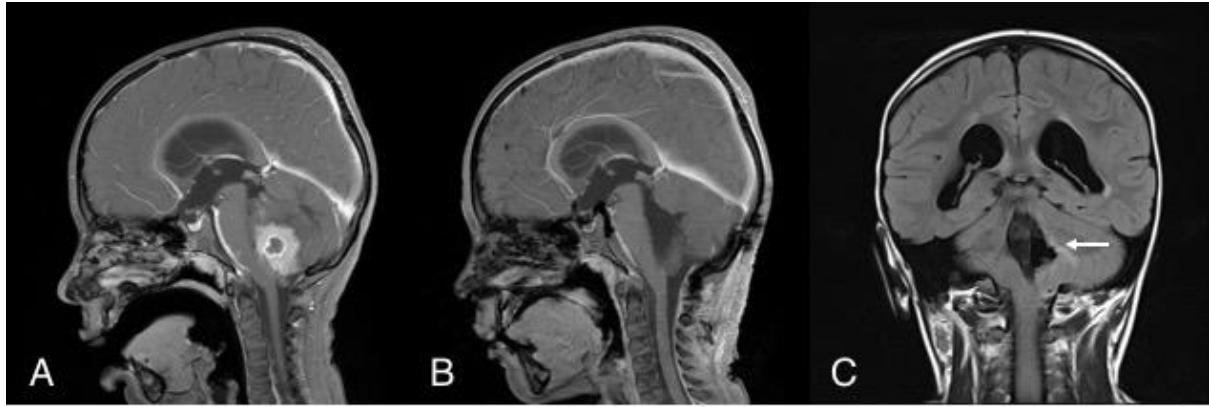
Conventional structural MRI scans of a patient with medulloblastoma, who developed pCMS after surgical resection at our institution. A, pre-operative sagittal T1-weighted post-Gadolinium; B, post-operative sagittal T1-weighted post-Gadolinium; C, post-operative coronal FLAIR sequences. Note the gross total resection of tumour and signal change in the region of the left dentate nucleus (white arrow), extending rostrally towards the ipsilateral superior cerebellar peduncle.
